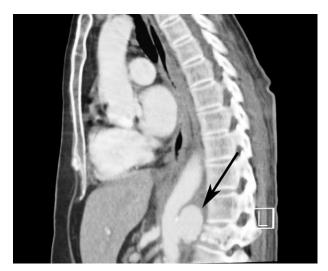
CT-scan, saggital view of a saccular aneurysm and surrounding haematoma.
